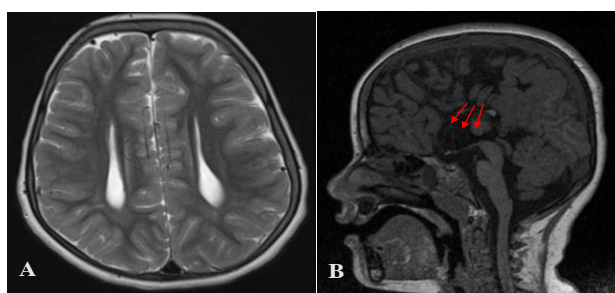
(A and B): Dysgenesis of corpus callosum with colpocephaly in a 6-year-old female preterm born child presenting with global DD. T2W axial MR image showing widely spaced parallel oriented bodies of bilateral lateral ventricle ("racing car sign") and dilated trigones. T1W sagittal MR image showing absent genu and rostrum of corpus callosum with markedly hypoplastic body and splenium.
